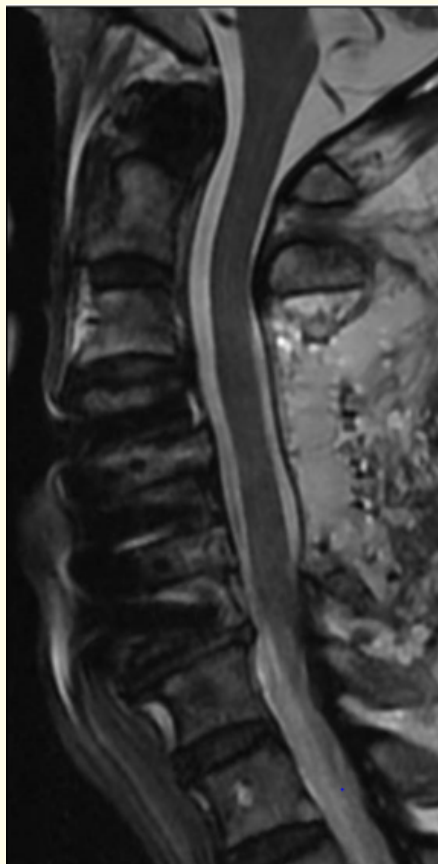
Sagittal MRI two weeks after decompressive laminectomy demonstrated complete spinal cord decompression.
